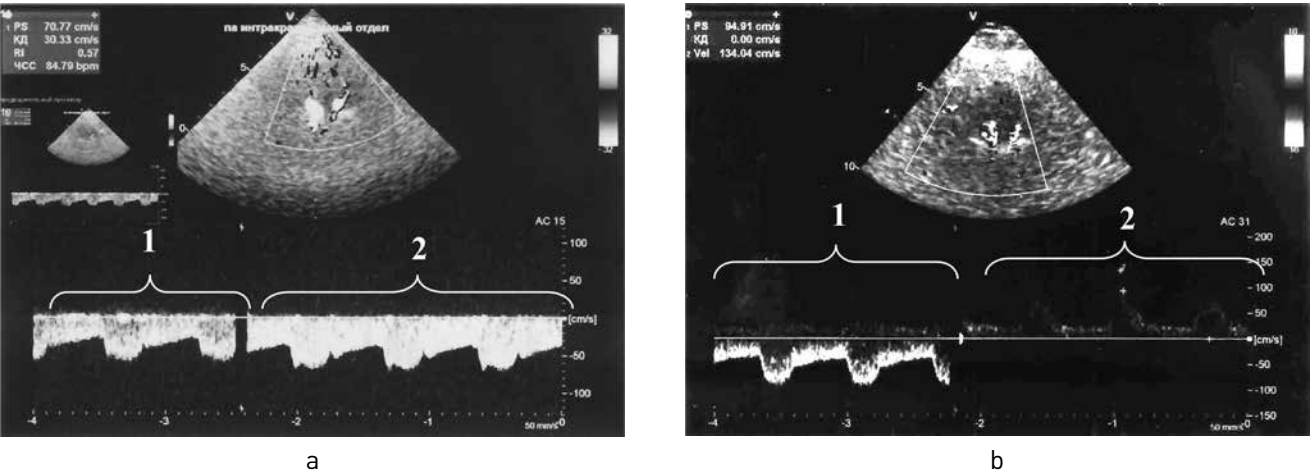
Blood flow in the vertebral artery in transcranial doppler ultrasound on the extracranial level on the left (1) and right (2): a — in a healthy individual; b — in subclavian steal syndrome
